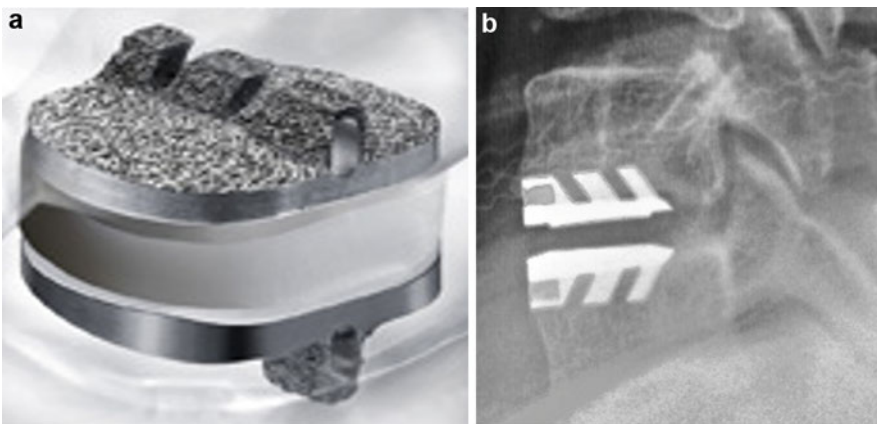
Secure-C cervical disc: (a) device; (b) lateral X-ray after implantation
